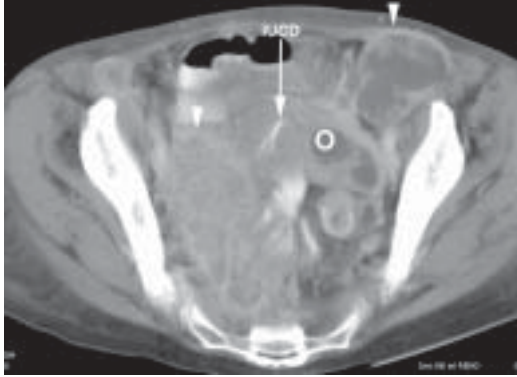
Computed tomographic scan of the pelvis. An IUCD is seen within the uterus (arrow). A complex mass is seen in the left adnexa consistent with a tubo-ovarian abscess (O). In addition, abnormal lymphadenopathy is seen within the left inguinal region and along the right pelvic sidewall (arrow heads).
